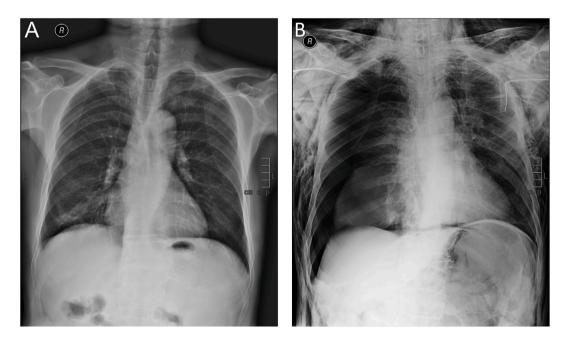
Perioperative chest anteroposterior radiograph of the patient. Prior to the surgery, the patient's chest radiograph A indicated no evident abnormalities. On the day of the surgery, the postoperative chest radiograph B revealed bilateral pneumothorax accompanied by extensive subcutaneous emphysema in the chest and neck regions.
